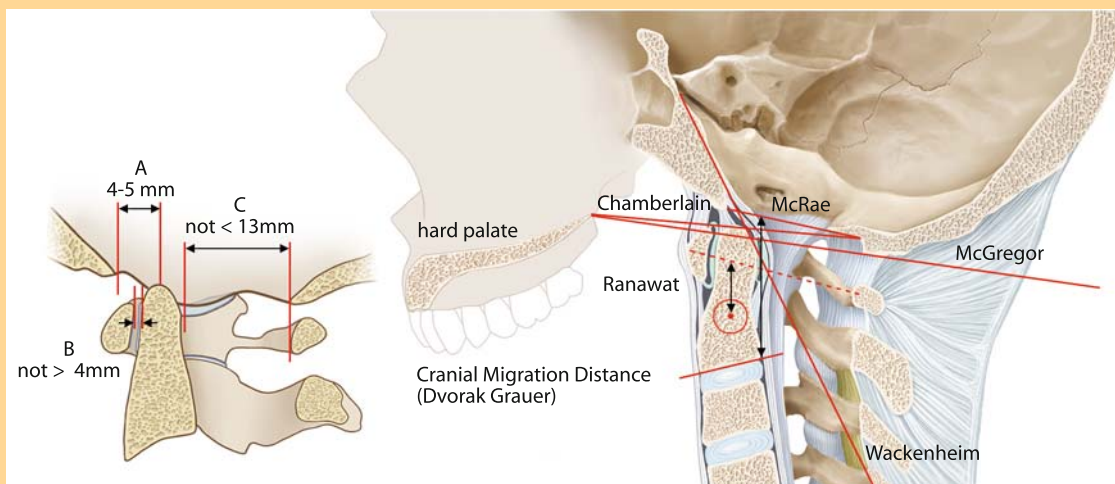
Radiographic assessment of instability
